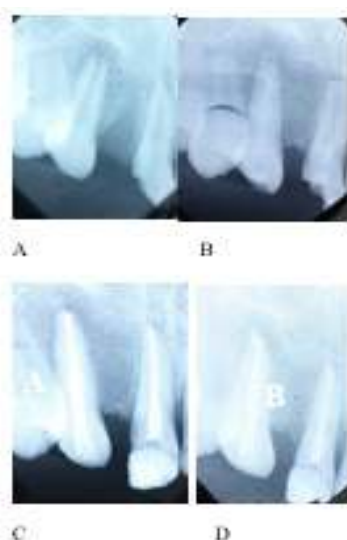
(A) Diagnostic periapical radiograph of 13 and 11. (B) Periapical radiograph showed root end closure on 13 after approximately four months treated with calcium hydroxide. (C) Obturation of 13 and 11. (D) One week after obturation of 13 and 11.
